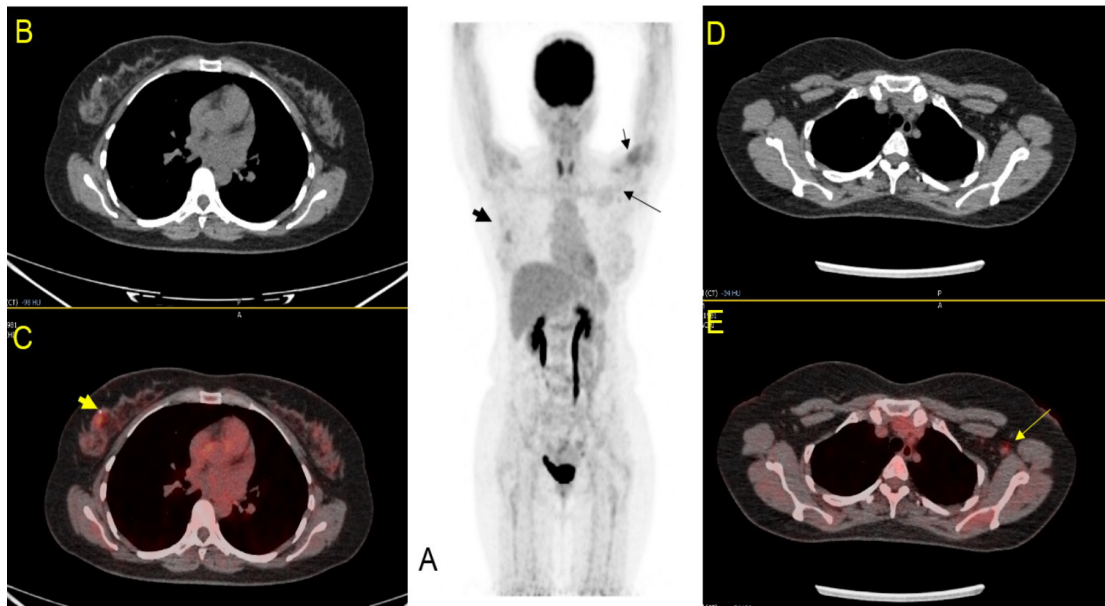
45 Years Female, CA Right Breast for Staging, h/o COVID-19 Vaccine in Left Deltoid within 4 Weeks. Focal ^{18}F FDG uptake seen over right breast (thick arrow in 1A & 1C). Double Sign seen on left (left deltoid injection site [small arrow in 1A] and small node in left axilla [long arrow in 1A & 1E]).
